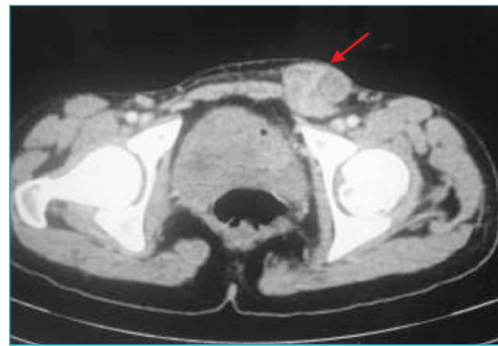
An axial section imaging of computed tomography intravenous pyelography showing ectopic location of left ovary in the subcutaneous plane in inguinal region (marked with arrow).
